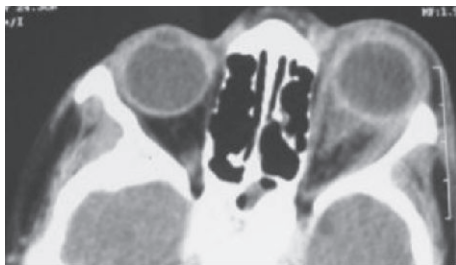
CT scan (axial view) showing multiple loss of tissue planes in the left orbit.
